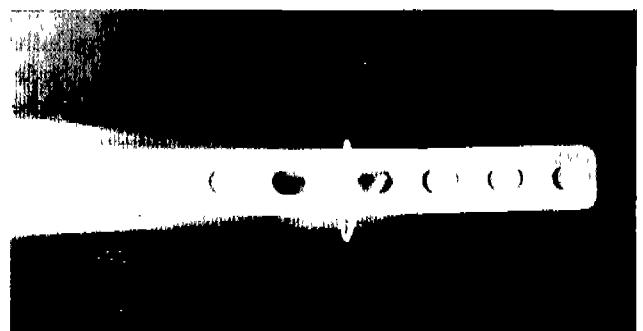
Radiograph taken immediately after surgery. 6/28/90.
